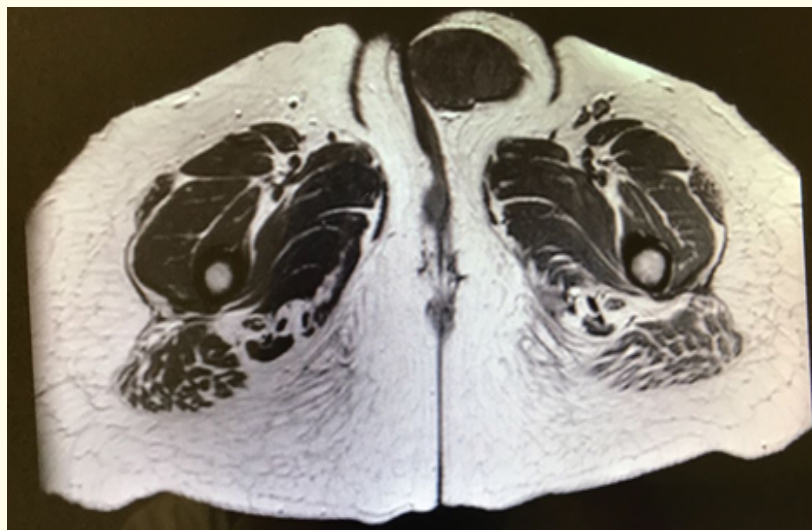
MRI showed a soft tissue mass in the left labia.
